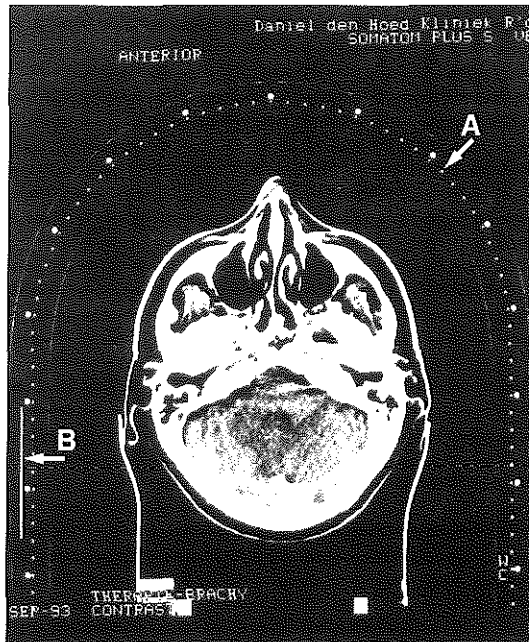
CT-scan image of immobilized patient with the noninvasive external localization frame. (A) Parallel rods depicted as dots; (B) Lucite triangle depicted as a line.
